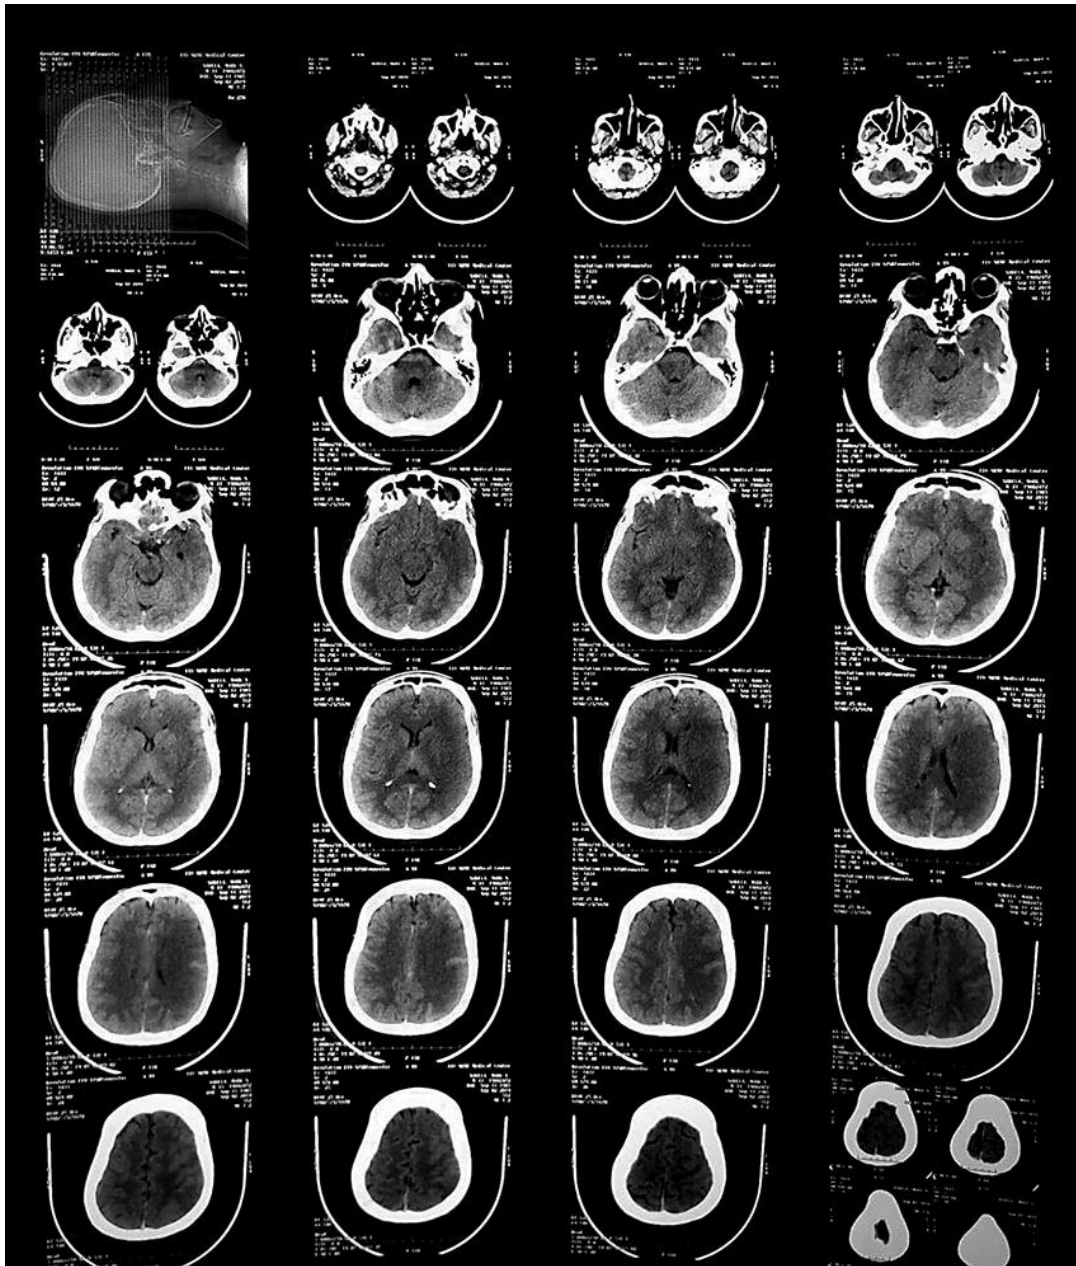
Non-contrast CT done 5 h from the stroke onset.
